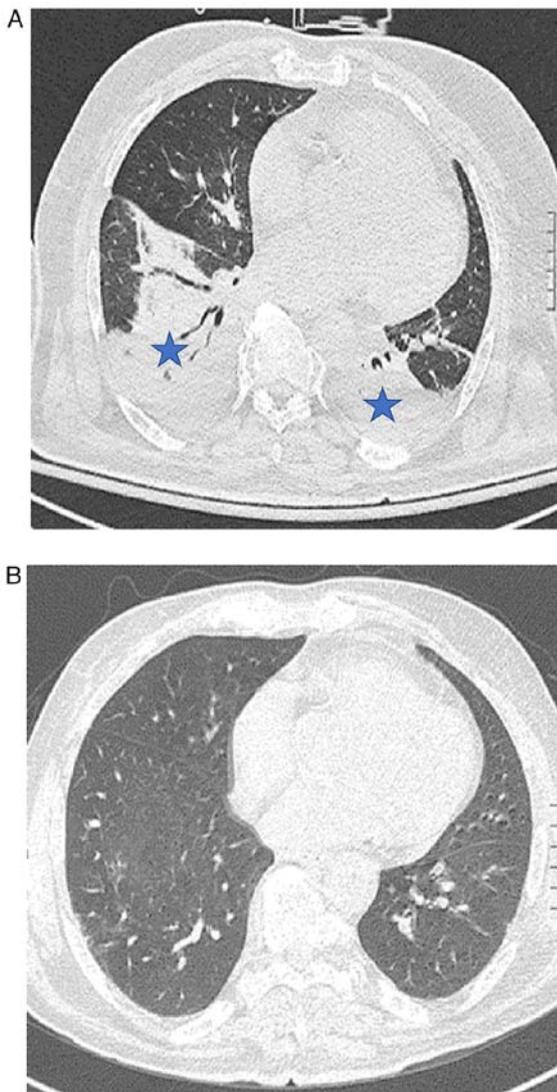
(A) Chest CT scan of the patient at the time of the diagnosis of ventilator-associated pneumonia. Blue stars indicate bilateral basal opacities with pleural effusion. (B) Chest CT scan following treatment with antibiotics. CT, computed tomography.
